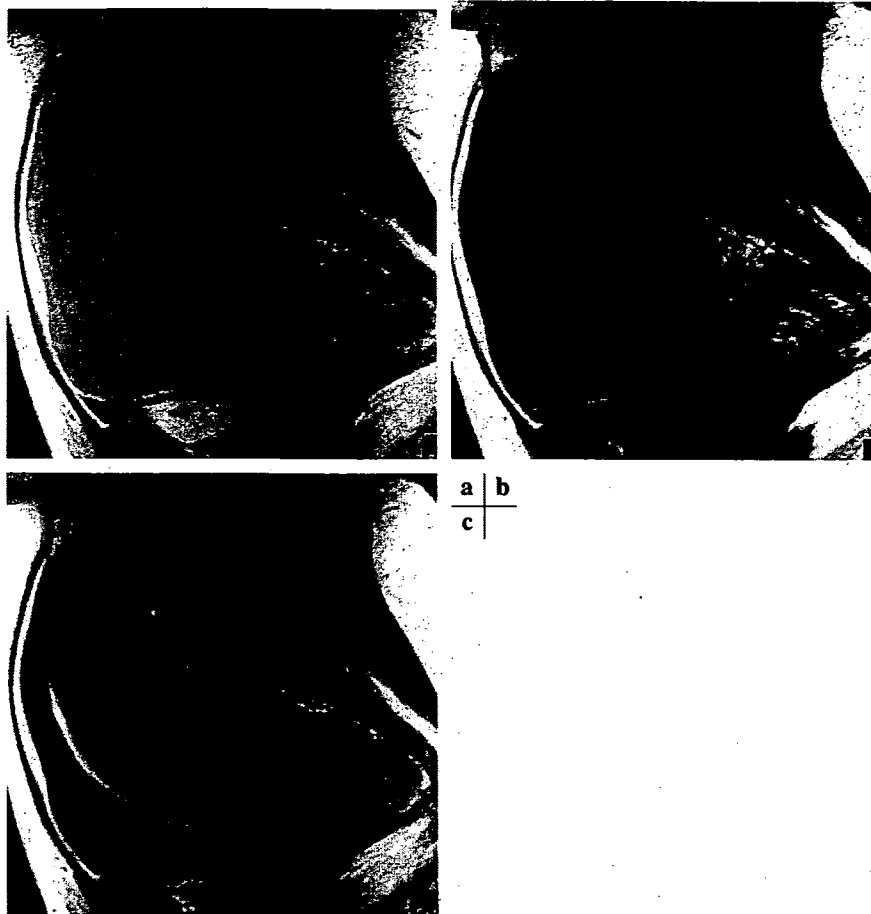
A 48-year-old woman with huge adenomyosis. Postcontrast T₁-weighted sagittal MR image (a) shows nodular-shaped hypointensity in the portion compressed by the sacral promontory. Compared with hypointense areas seen in patients with leiomyoma (Figs. 1 and 2), the margin is less irregular and relatively well defined. Precontrast T₁-weighted sagittal MR image (b) and T₂-weighted sagittal image (c) show no specific signal changes that correspond to the area seen in (a).
